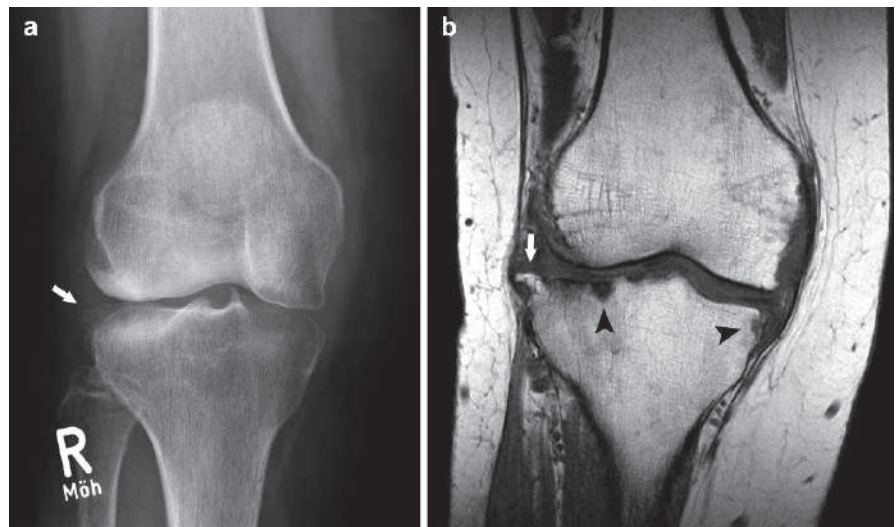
Plain knee radiograph (a) and coronal T1W knee MRI of the same patient shows subchondral cysts (black arrowheads) and marginal osteophyte in the lateral tibial plateau (white arrows)
